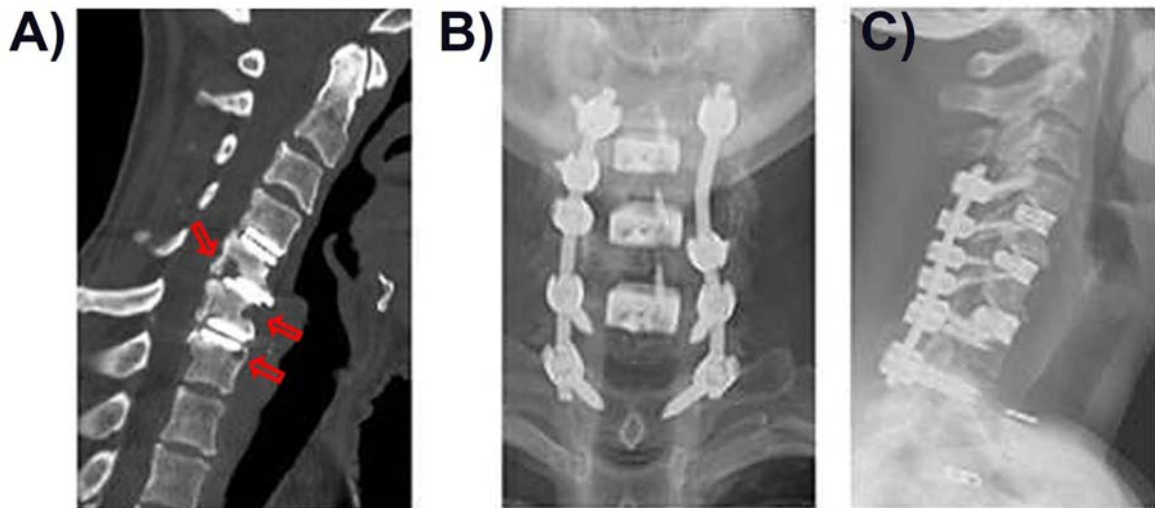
A) Pre-op radiographic imaging of the patient with failed CTDR at C4-C7 level. Strong bone remodeling and osteolytic lesion can be seen at all three levels. B) and C) Post-op X-rays of the patient underwent implant removal, ACDF, and posterior cervical fusion.
